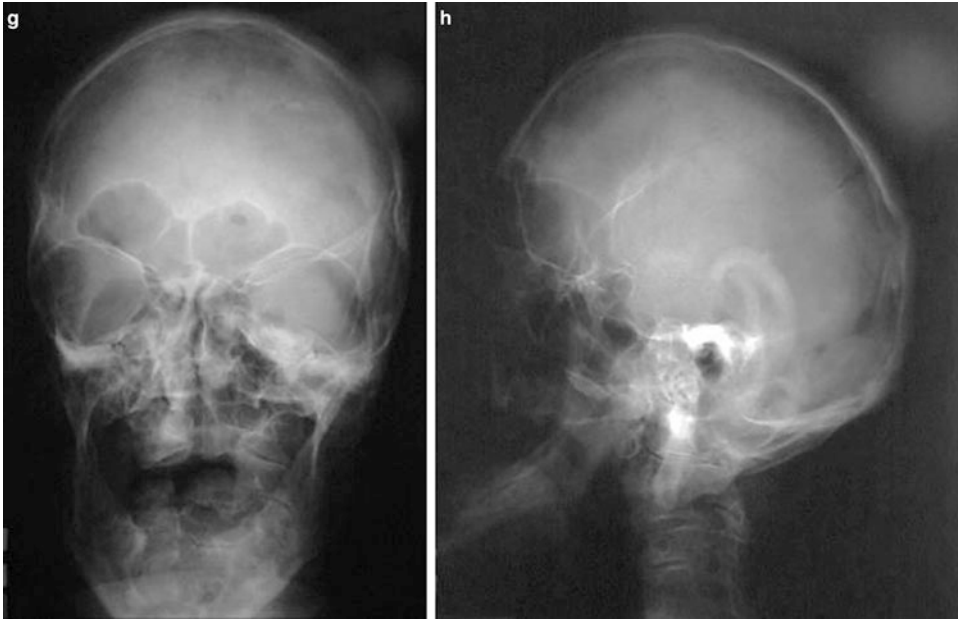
(a–h) An adult with Apert syndrome showing typical craniofacial appearance with mitten hands and socked feet. Radiographs of hands and feet and skull showed cutaneous and osseous syndactyly, turribrachycephaly, shallow orbits, and hypoplastic maxilla
